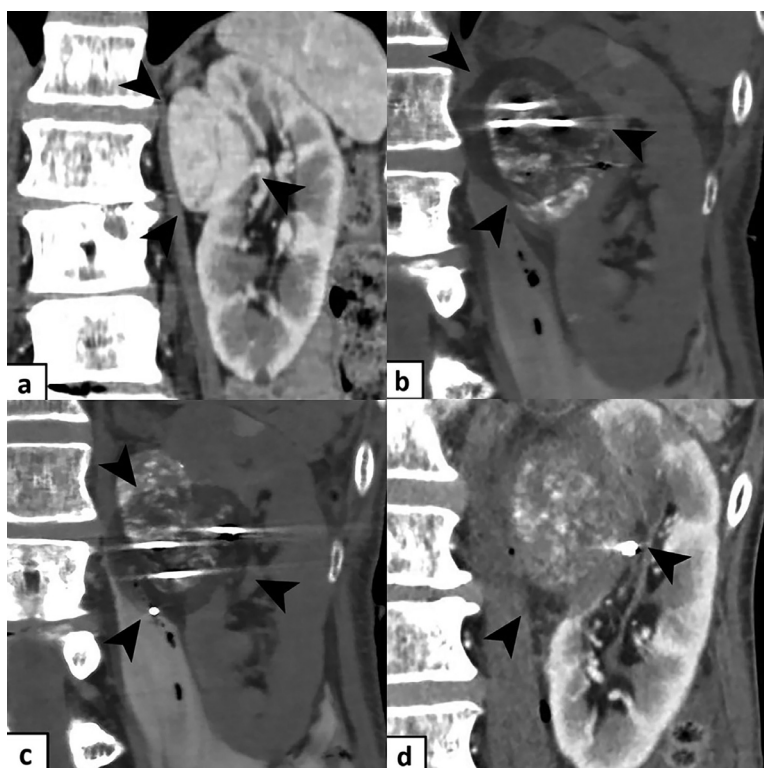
(a) Pretreatment contrast-enhanced computed tomography (CT) demonstrates a left renal tumor close to the renal pelvis; CT during cryoablation demonstrates a low-density area (i.e. ice ball) with 3 cryoprobes in the upper (b) and lower (c) parts of the tumor; (d) CT image 2 days after the cryoablation shows an ablation zone with an adequate treatment margin.
